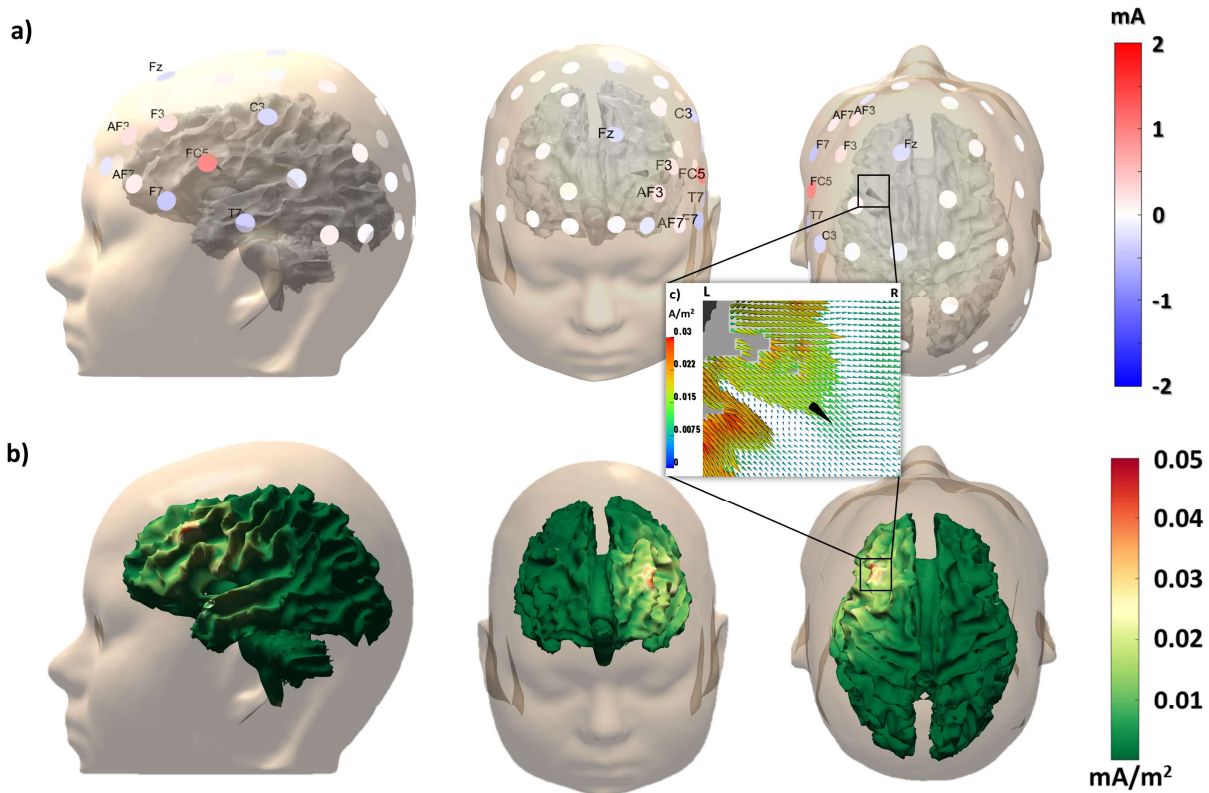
a) The optimized tDCS montage. The EEG-defined target is indicated as a black cone. b) the optimized current density distribution on the patient's cortex and c) an axial MRI in zoom-view mode of the optimized currents at the target area. The channels are colored by the optimized currents ranging from -2 up to 2 mA. The total sum of the of the injected currents was equal to 2 mA to fulfill safety constraint. The colored brain surface of the patient represents the distribution of the current density measured in mA/m². The visualization of the sub-pictures a) and b) were created in MATLAB by using our own scripts while the sub-picture c) was visualized by the use of openly available toolbox, Scirun⁴.
